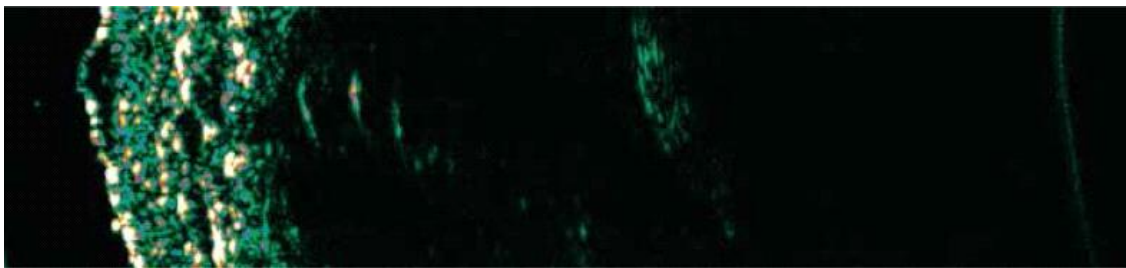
The figure shows an ultrasound image of superficial melanoma on the right forearm of a 64-year-old woman [12].
